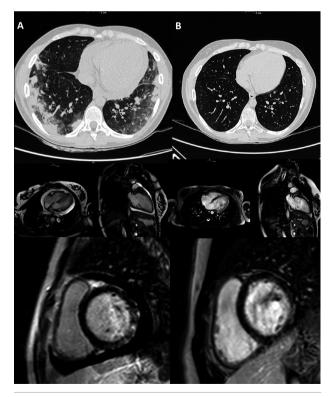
Chest high-resolution computed tomography and cardiac magnetic resonance imaging before (A) and after (B) therapy with rituximab.
